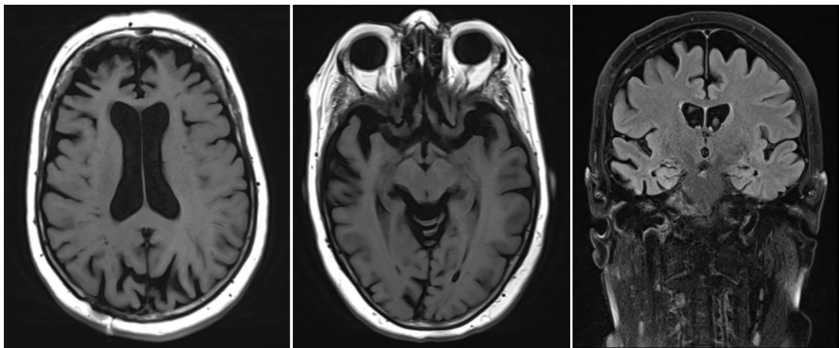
Brain MRI of the patient described in the clinical vignette.
